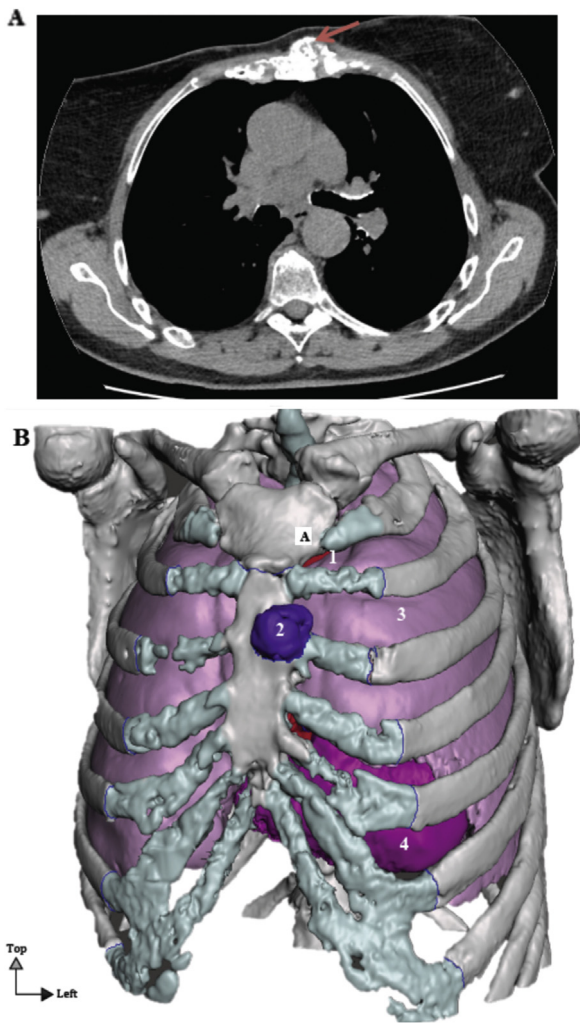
A: CT scan in axial section passing through Th7 (arrow representing the tumor). B: 3D model according to the preoperative CT scan in anterior view. (1: internal thoracic artery, 2: tumor, 3: upper lobe of the left lung, 4 tip of the left ventricle).
